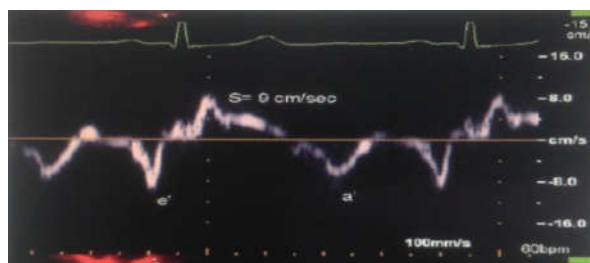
Doppler tissue imaging of the lateral mitral annulus.
